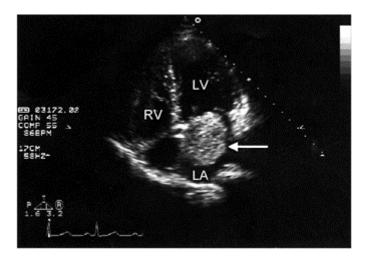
Transthoracic apical four-chamber view. Left atrial mass (arrow) consistent with large myxoma obstructs transmitral flow in diastole. LA: left atrium; LV: left ventricle; RV: right ventricle.
